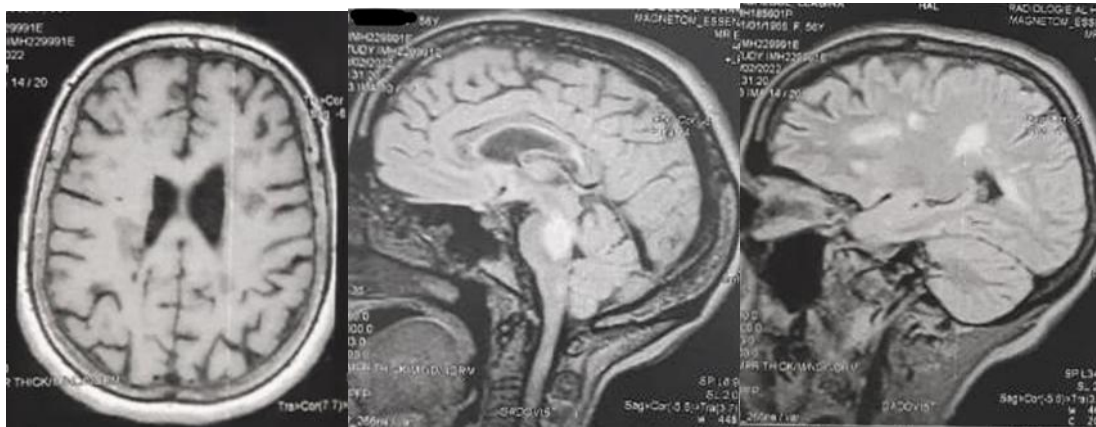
Brain MRI showing supratentorial and infratentorial demyelinating lesions with black holes
